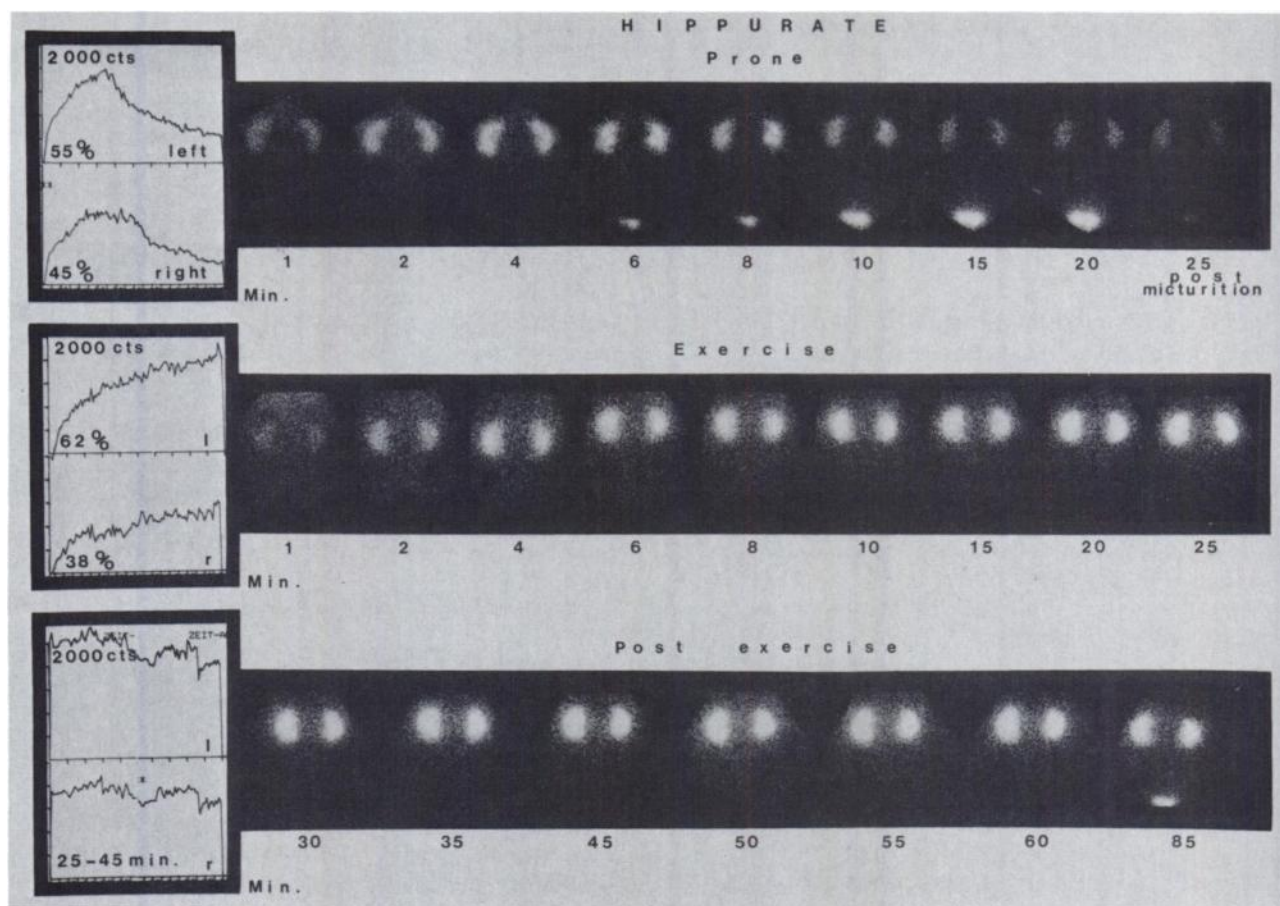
Renograms and sequential scintigrams of 48-yr-old hypertensive patient, examined both in prone position and during exercise. Sequence of examinations shows that exercise can initiate pronounced changes of tracer kinetics. Underlying vascular response appears inappropriate relative to stimulus. Prone examination demonstrated that left kidney contributed 55%, right kidney 45% of total function. Parenchymal tracer transport was slightly delayed. Exercise initiated massive disturbance of tracer kinetics. Note tissue retention of tracer and its lack of excretion into bladder during 20-min examination. Extended observation period demonstrated that tracer excretion into bladder had failed to occur at 60 min—40 min after termination of exercise. Late image at 85 min identified radiohippurate in bladder. Lower time-activity curves contain artifacts due to movement from one foot to other.
